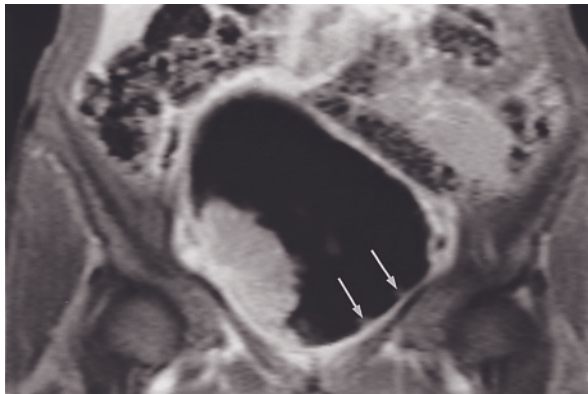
Invasive transitional cell carcinoma. Sagittal (a) and transverse (b) T2-weighted single-shot echo-train spin-echo and sagittal (c) and transverse (d) T1-weighted gadolinium-enhanced fat-suppressed SGE images. Markedly diffuse thickening of the bladder wall (a, b) is present, which represents diffuse tumor involvement. The tumor enhances intensely after gadolinium administration (c, d). T2-weighted echo-train spin-echo (e), T1-weighted gadolinium-enhanced fat-suppressed spin-echo (f), and coronal
